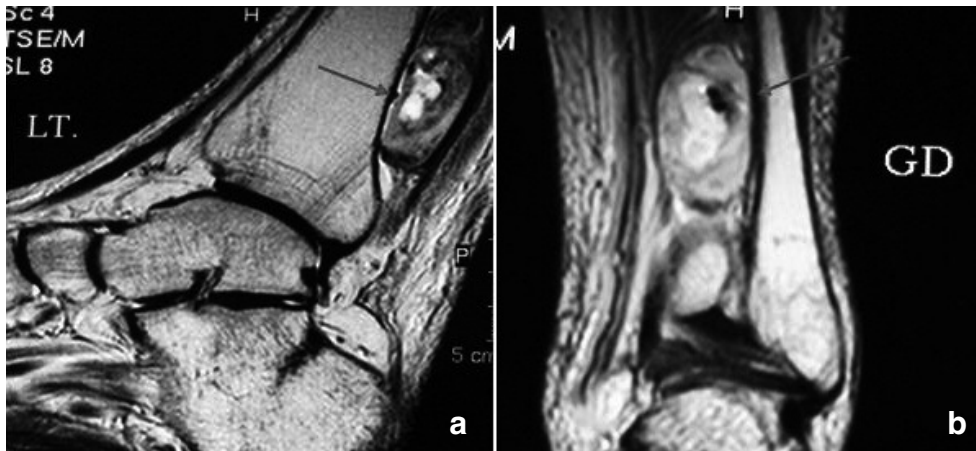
T2 weighted and post contrast MR images: a lesion demonstrated in distal of left leg posterior to tibia (arrows). It has inhomogenous iso and hypersignal intensity on T2 weighted image and showing diffuse enhancement on post contrast image.
